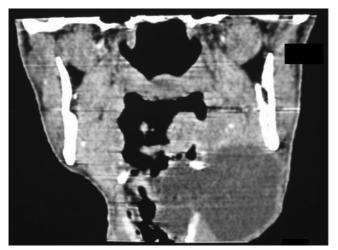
Coronal computed tomography scan showing the mass arising from the left ventricle of the larynx passing through the thyrohyoid membrane to reach the lateral aspect of the neck.
